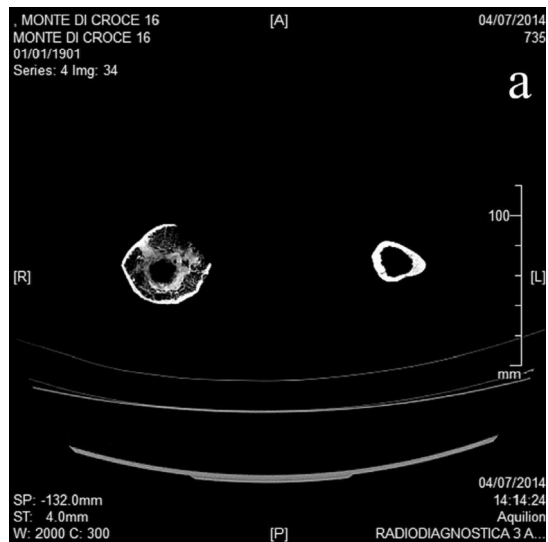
Cross-sections of the tibiae at CT: narrowing of the medullary canal by sclerotic new bone, circumferential cortical thickening and areas of osteolysis are evident at the level of the metaphysis (a) and superior third of the diaphysis (b); complete obliteration of the medullary canal is visible at the level of midshaft (c); tracts of the original tibial diaphysis are well recognizable in all sections
